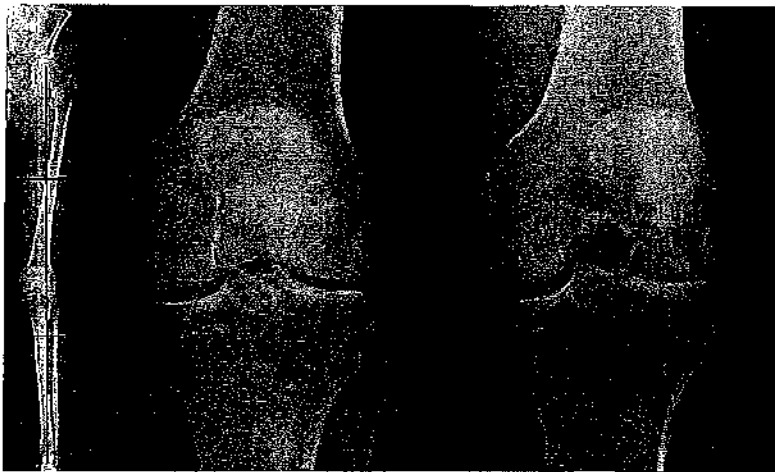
◀ Typical lateral compartment osteoarthritic left knee. Valgus leg alignment on full leg weight bearing radiograph with weight bearing line (in red) passing through the lateral compartment (left), weight bearing antero-posterior (AP) knee radiograph in extension shows small lateral joint space narrowing (middle), weight bearing postero-anterior (PA) knee radiograph in 45° flexion (Rosenberg view) shows severe lateral joint space narrowing (right). (With permission from [60], Fig. 1, page 127)
